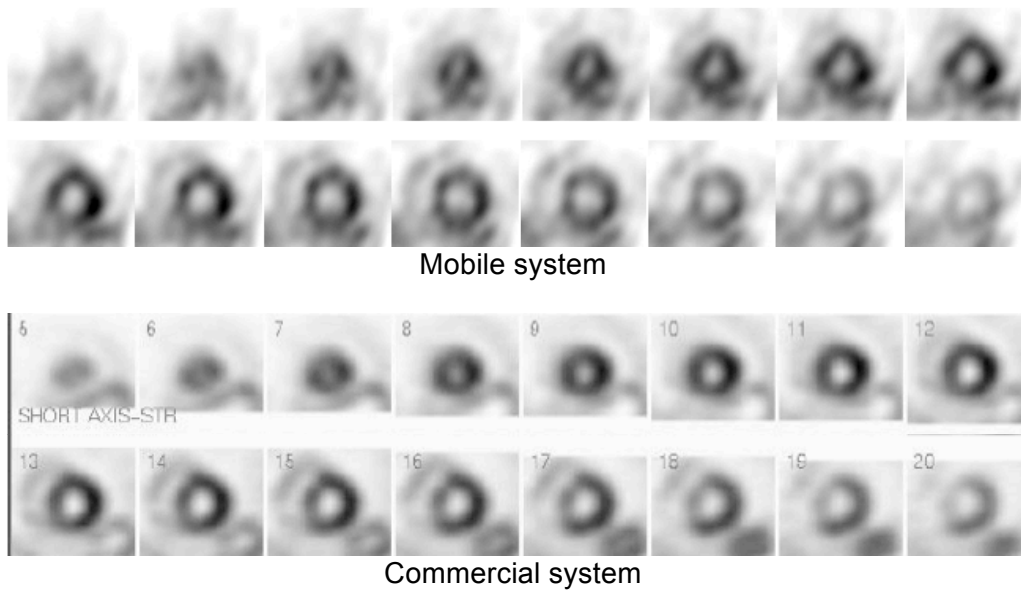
Comparison of reconstructed images of a patient Tc-99m sestamibi study from the mobile system (top two rows) and a commercial SPECT system (bottom two rows).
